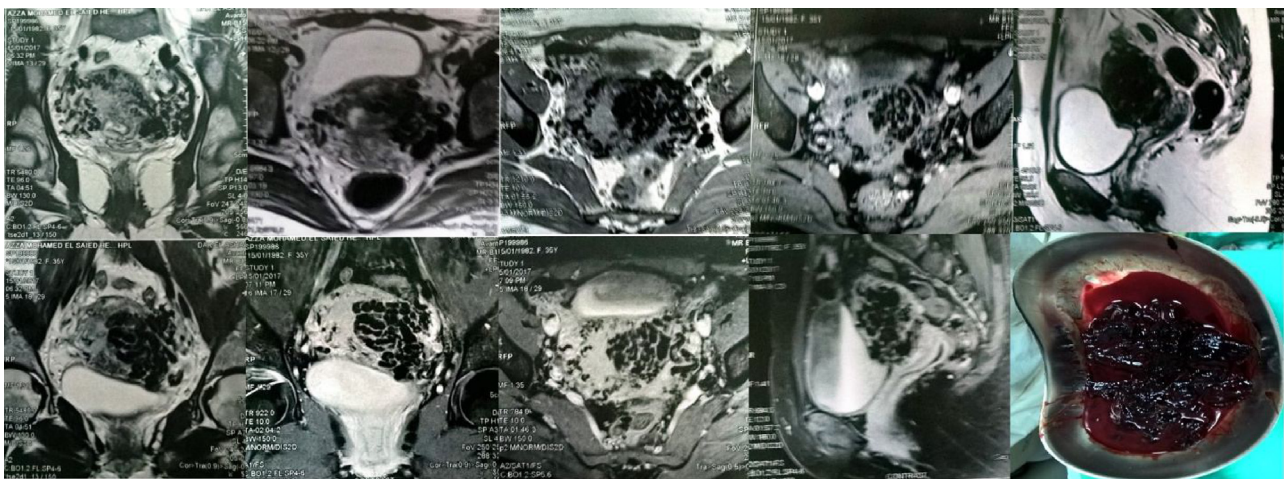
MRI revealing large mass involving most of the uterine wall with large tortuous dilated myometrial blood vessels and large parametrial ones. Blood clots retrieved from the patient vagina in the last photo.
